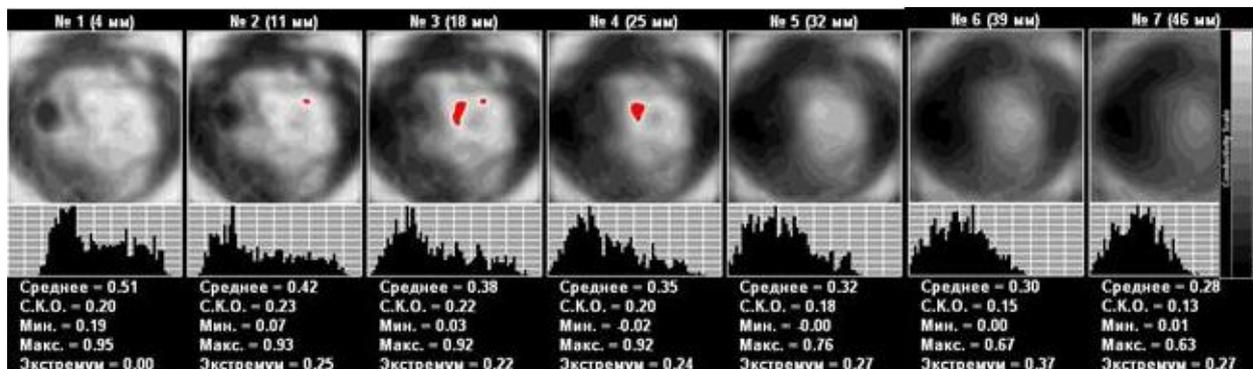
EIM. Outer segment. Mixed type of mammary gland structure. In the outer segment of the left gland there is observed an an-impedance area, which is highlighted with red in three scan planes, 7x14 mm in size. ULTRASOUND: A 0.7x1.0 cm lesion of low echogenicity is located in the upper-outer segment of the left mammary gland. Axillary lymph nodes are enlarged.
